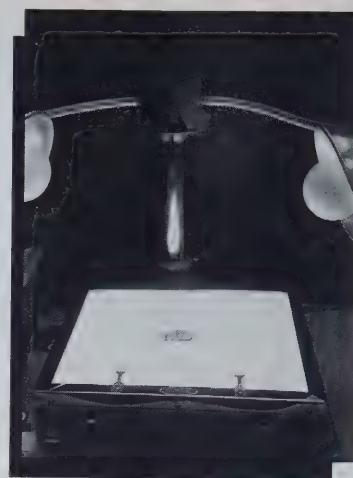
Lightbox with radiograph and video camera.
